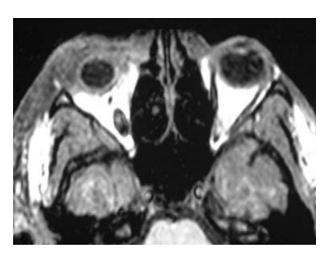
MRI of orbits taken post-admission day four.
